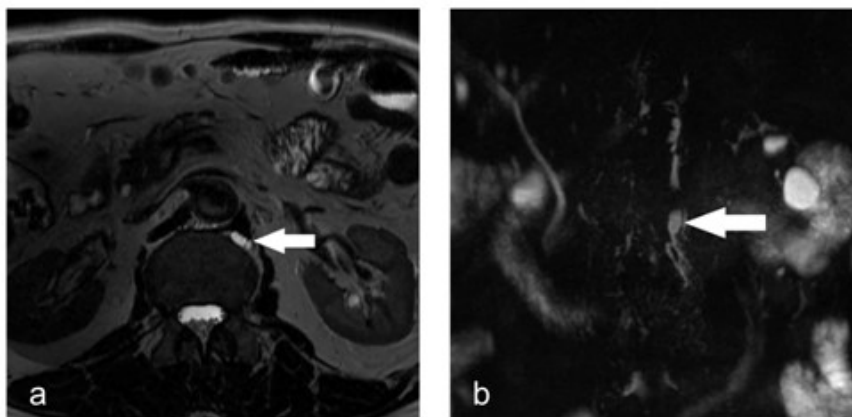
Left-sided CC in a 69-year-old male patient undergoing MRCP for pancreatic cyst follow-up. Axial 2D (3T, TR 2210.52 ms, TE 250.9 ms) MR image (a) and coronal 3D MIP (3T, TR 3157.90 ms, TE 579.0 ms) MR image (b) demonstrate a left-sided CC (arrows).
